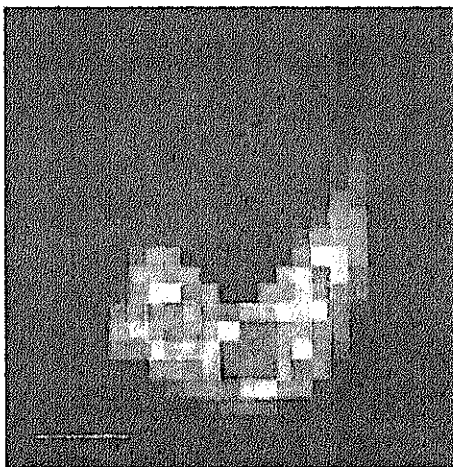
Fluorescent x-ray CT image of thyroid cancer at 1-mm spatial resolution.
